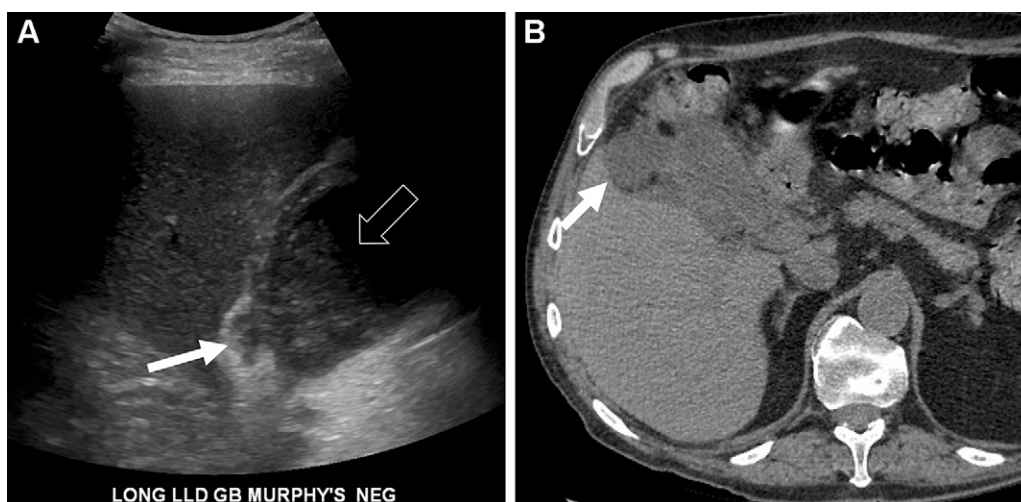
Perforated cholecystitis resulting in progressive decompression of the gallbladder in a 72-year-old man. (A) Gray-scale US image shows a focal defect in the gallbladder wall with extrusion of intraluminal contents (solid arrow). There is intraluminal sludge (open arrow). The sonographic Murphy sign was negative in this patient. (B) Axial noncontrast CT image obtained several hours later shows further decompression of the gallbladder due to further extrusion of intraluminal contents out of the gallbladder (arrow).
